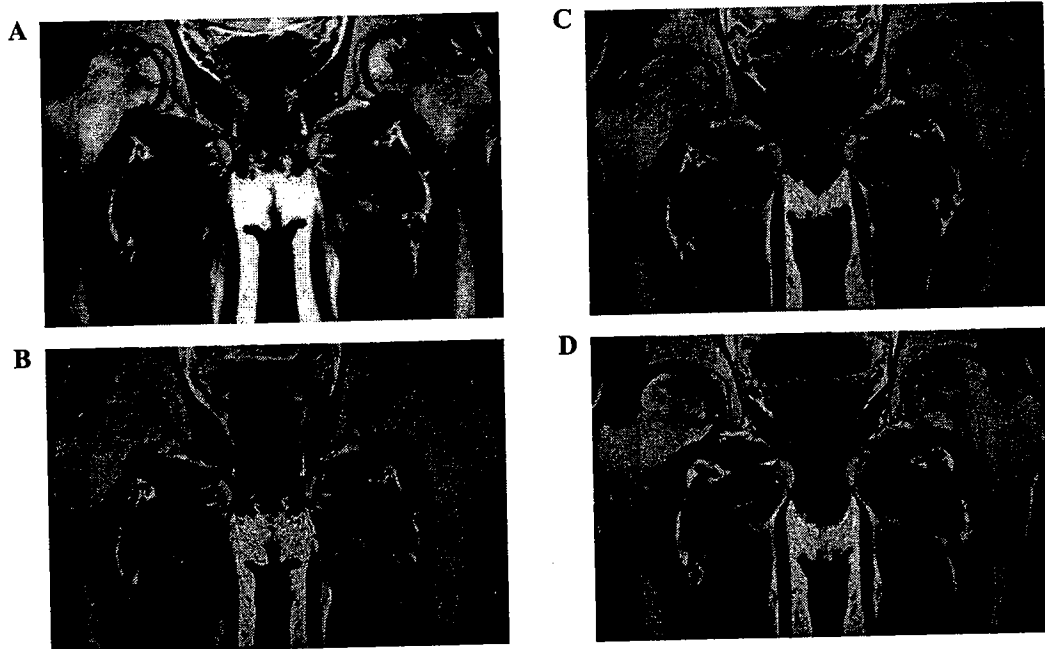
Follow-up gadolinium-enhanced T1-weighted magnetic resonance image of an HIV-infected patient showing gradual progression of osteonecrosis. (A) Grade II osteonecrosis over the left femoral head and grade III osteonecrosis over the right side were present with geographic interscapular lesions bilaterally. (B) In the serial non-enhanced T1-weighted images, osteonecrosis of the left hip joint progressed to a grade III lesion at 20 months after diagnosis. A slow progression was observed at 27 months (C) and 36 months (D) after diagnosis.
